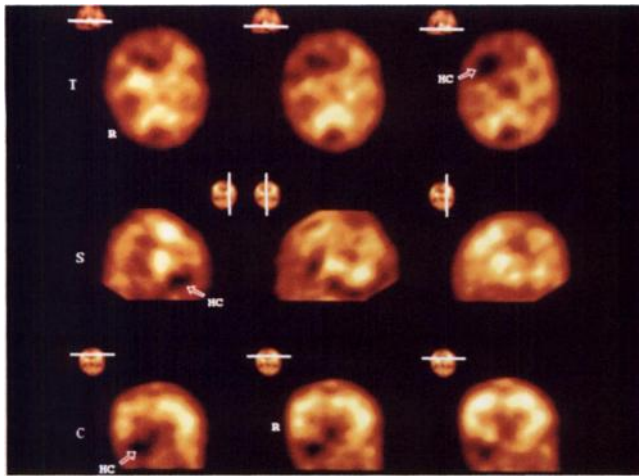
Focal decrease in rCBF in ipsilateral hemisphere (Patient 9). SPECT following veno-venous ECMO demonstrated an area of decreased perfusion (open arrow) in the right fronto-temporal region. US and MRI (Fig. 8) showed hemorrhagic infarct in the same region.
